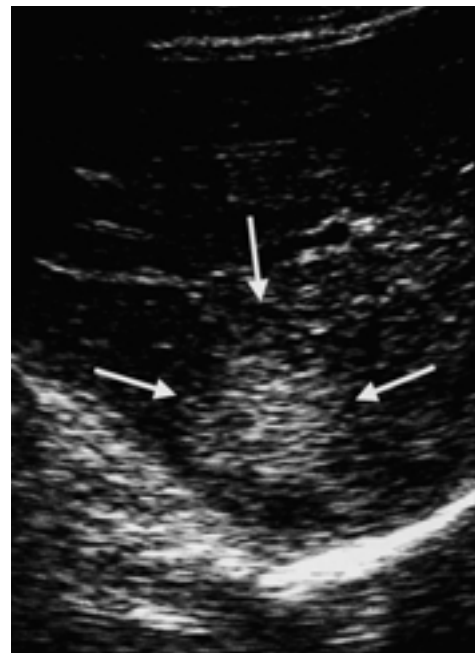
Sonography shows a echogenic lesion with a subtle hypoechoic rim in the right lobe of the liver (arrows).
